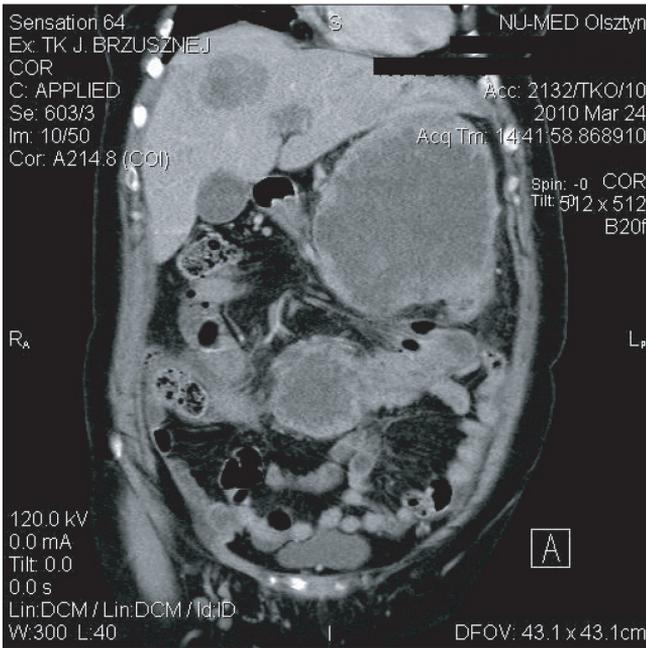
Abdominal CT scan. Tumor masses in multiple localizations
